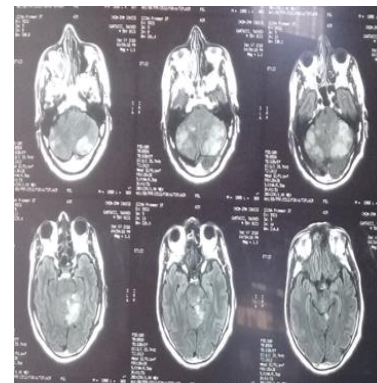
Third cerebral MRI
